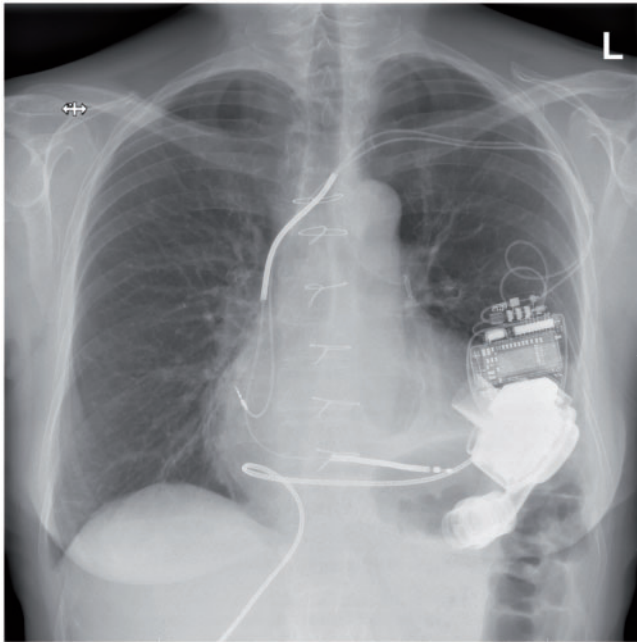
Chest X-ray, showing the HeartMate3, CardioMEMS and biventricular ICD. ICD: implantable cardioverter-defibrillator.
